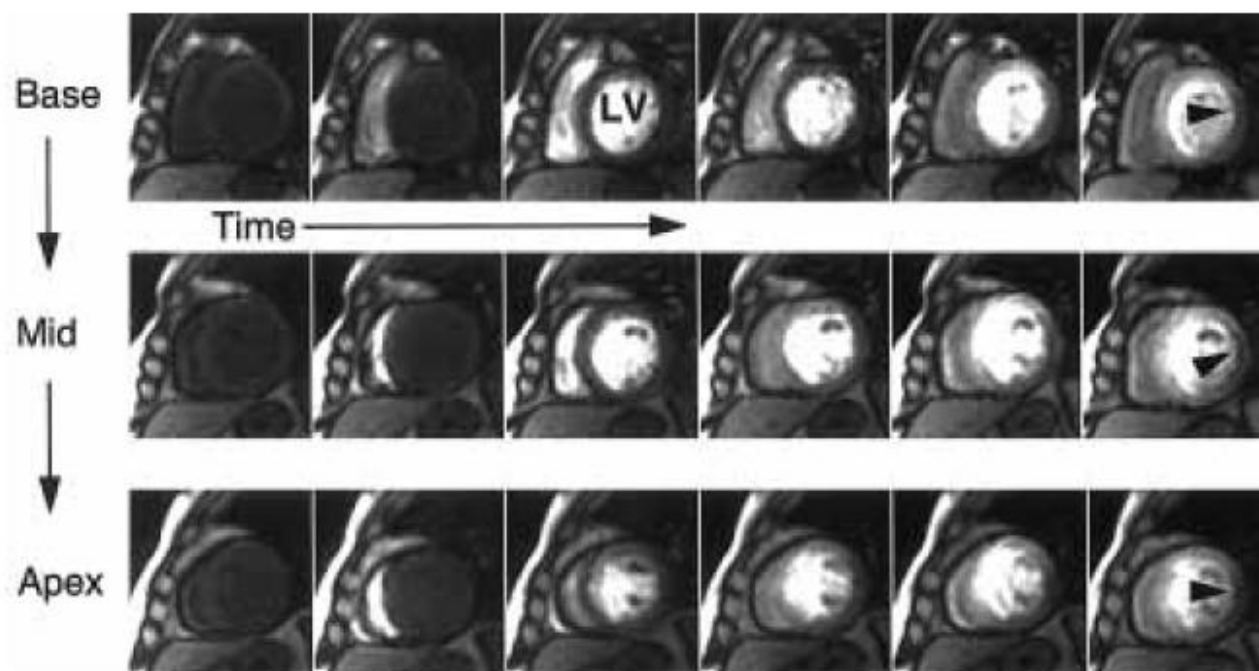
First images acquired with the AICE technique in a patient post angioplasty 2 hours after acute myocardial infarction. X-ray angiography pre and post angioplasty suggested that the patency of the LCx was successfully restored with a remaining 25% stenosis.
